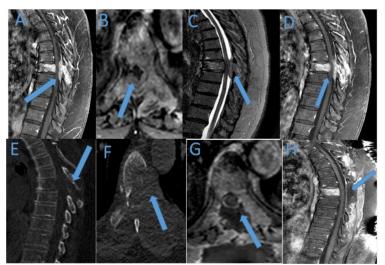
A-D, A 74-year-old female patient with primary lung cancer. Preoperative thoracic sagittal and axial MR images (T1-T2 image and contrast unenhanced). Metastatic mass causing pressure on spinal cord epidural space at the T7 level. E-F, Thoracal CT and CT sagittal reconstruction images. In addition to spinal cord compression in the epidural area, a mass erodes in the bone tissue (arrows). G-H, Postoperative axial and sagittal T1 MR images. The mass was removed with total laminectomy, and the spinal cord pressure was released (arrow).
